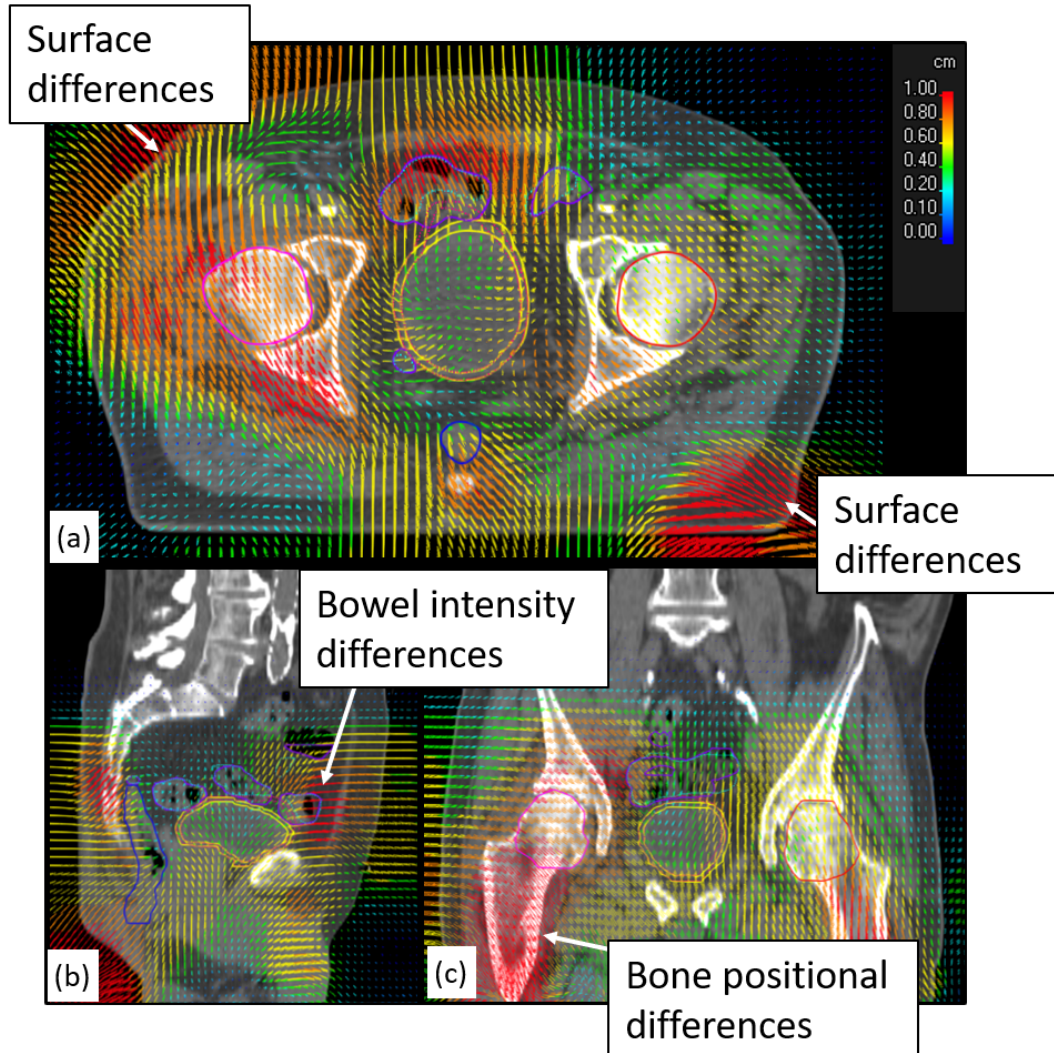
Deformable registration (DR) mapping vectors between CBCT and CT shown overlaid upon the planning CT for (a) transaxial, (b) sagittal and (c) coronal views.
